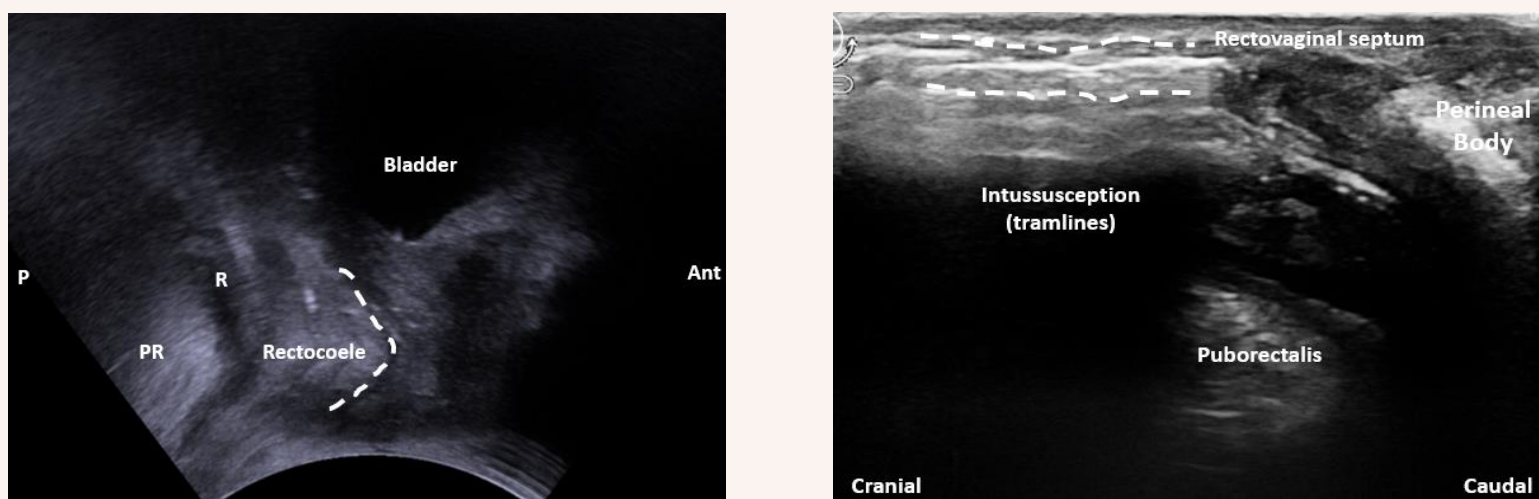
Figure (left) – Transperineal ultrasound and (right) – Posterior Transvaginal ultrasound
